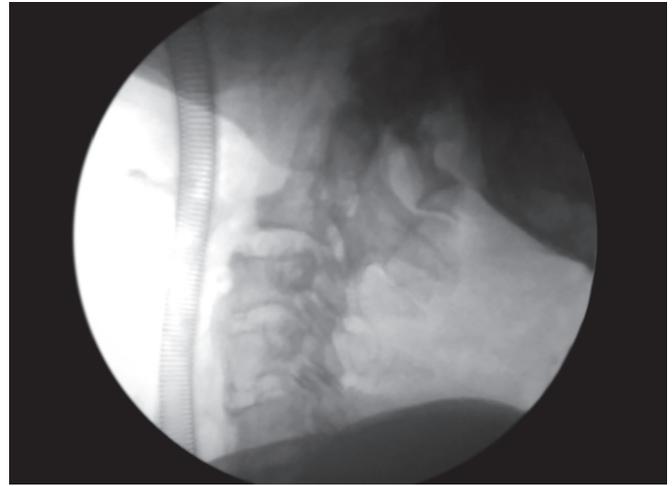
Postoperative X-ray cervical spine after C2-C3 anterior osteophyte excision
